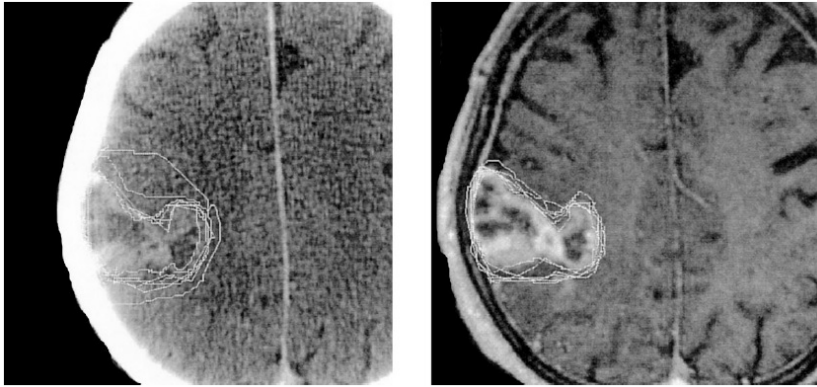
GTV delineation by nine different observers on an axial CT image (left) and an axial MRI image (right). Figure from [24].
